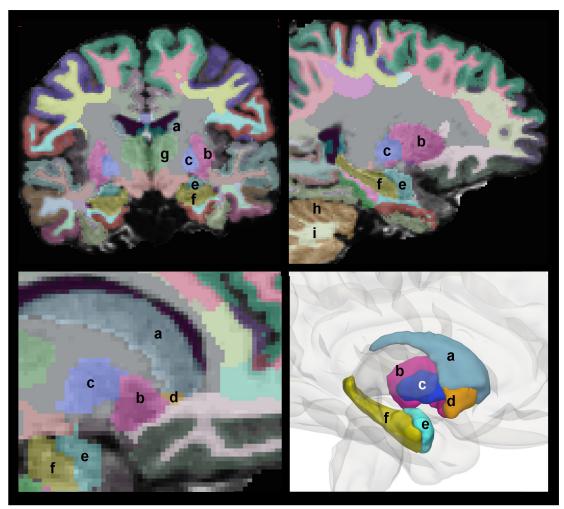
Segmentation. The first three panels show the segmentation as a coloured overlay on the MR images of one participant, in (from top left) coronal view, sagittal view and close-up of another sagittal view. In addition to the subcortical structures, white matter and cortical parcellations are also given different colours in these images, but the reader may only concider the subcortical structures which here are given letters. a = caudate, b = putamen, c = pallidum, d = accumbens area, e = amygdala, f = hippocampus, g = thalamus, h = cerebellum cortex, i = cerebellum white matter. The bottom right panel shows a 3D rendering of some of these subcortical structures, based on an average of participants, using Slicer software.
